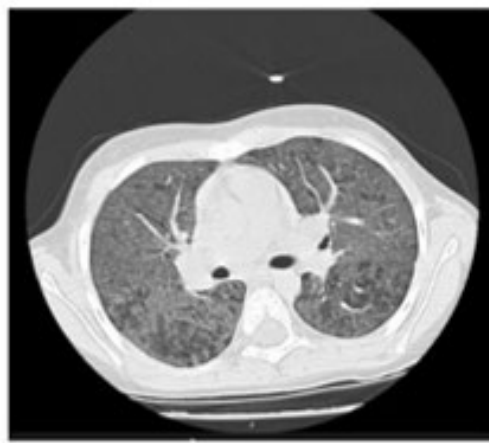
CT scan showing bilateral and diffuse ground glass densification, compatible with an exuberant and nonspecific interstitial pneumonitis, no other pleuroparenchymal alterations were founded as well as no alterations in the mediastinum, adenopathy, pleural or pericardial effusion.
